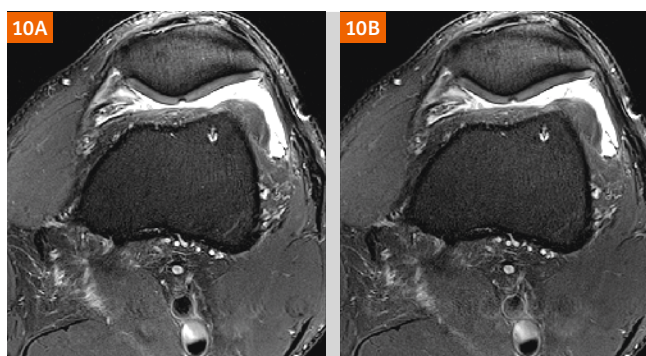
Axial TSE T2-weighted scans of the knee at 3T depicting patellar cartilage damage, in a patient with prior medial collateral ligament and anterior cruciate ligament surgery, on images (10A) without and (10B) with SMS (2 acceleration). Image quality is equivalent, with SMS allowing a reduction in scan time from 7:14 to 3:48 min. In plane resolution is 0.4 x 0.4 mm².
